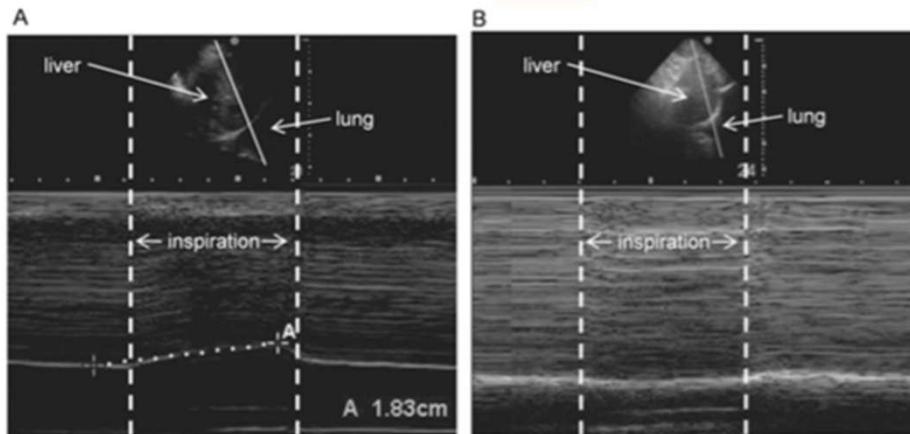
Ultrasonographic M-mode images from the right hemidiaphragm. (A) Normal diaphragm motion: the diaphragm moves 1.8 cm cephalad during inspiration. (B) Caudal movement of the diaphragm in a patient with diaphragm paralysis.
